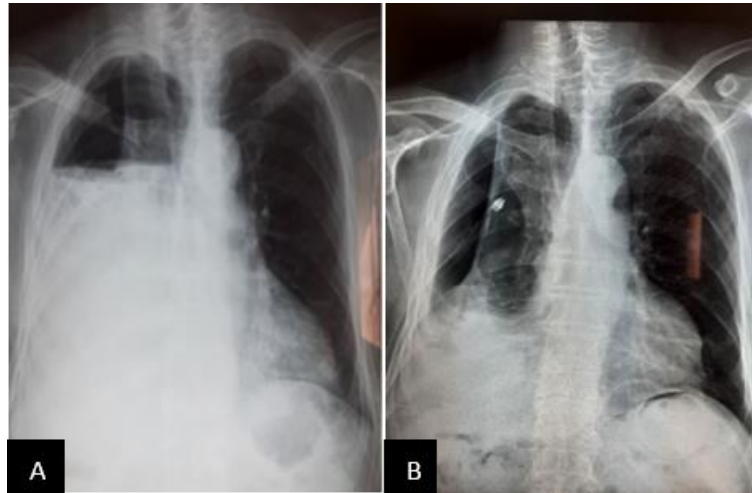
Chest X-ray showing a hydroaeric image occupying the whole of the right hemithorax (A: Pyopneumothorax before chest drainage; B: after medical chest drainage).
